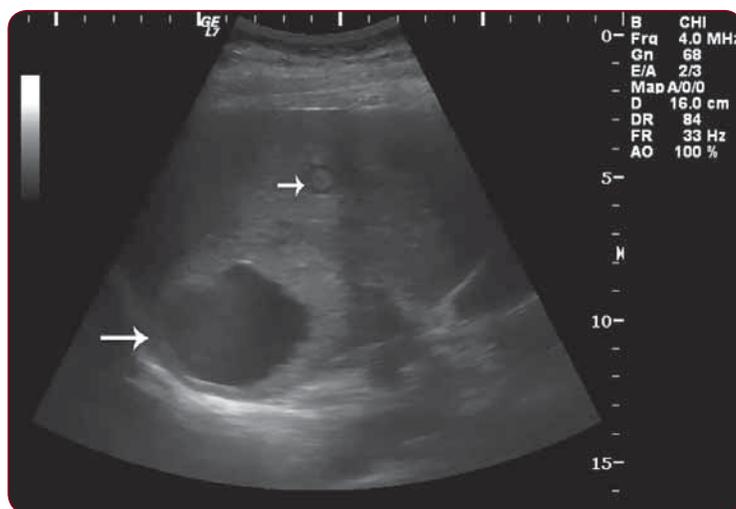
Abdominal ultrasonography which shows many liver tumours; big arrow points to cystic tumour, small arrow points to a solid tumour
